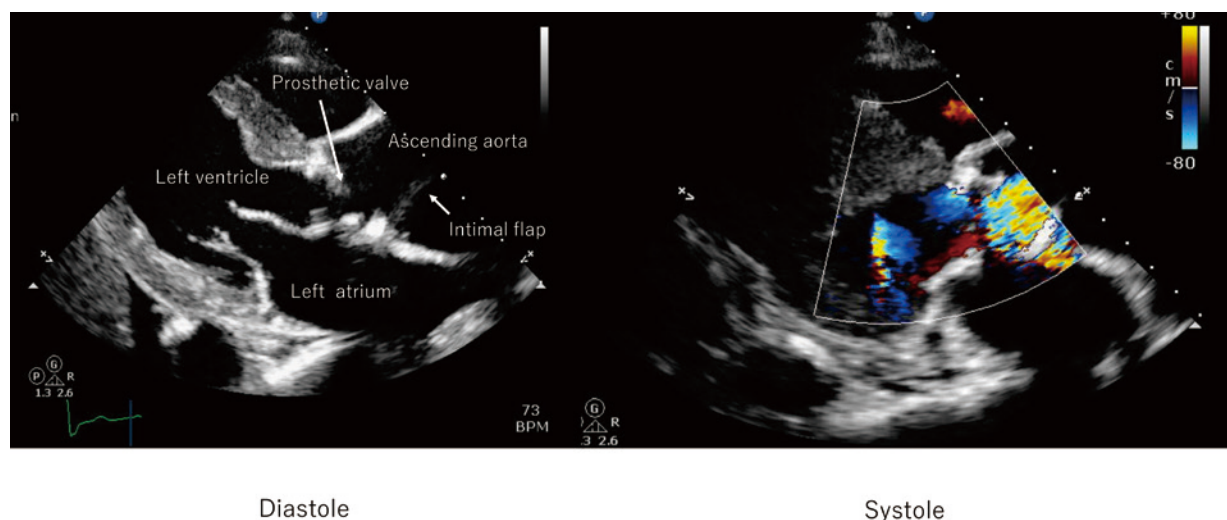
Preoperative echocardiography (diastole and systole)
